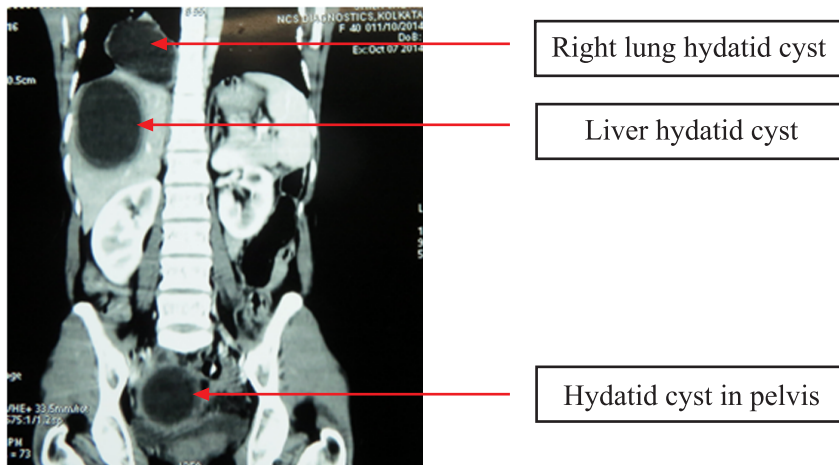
CT Scan Showing Hydatid Cyst in Right Lung, Liver and Pelvis
